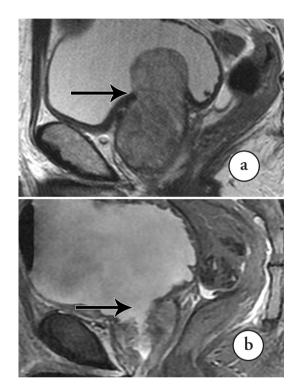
Magnetic resonance imaging showing a) before and b) after the procedure. Prostate volume as determined by MRI varied from approximately 103.1 ml before the operation to 39.9 ml after the treatment and 61.6 g adenoma were resected. The applied laser energy was 69.8 kJ and the surgical time was 61.5 minutes. (Arrows denote the resection of large prostate adenoma)
